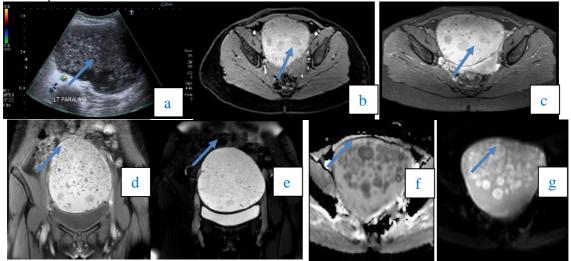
Grey scale Ultrasound image (a) showing a large complex (cystic and solid), avascular left adnexal mass with multiple internal echogenic foci. MRI axial T1WI pre (b) and post contrast (c) showing a non-enhancing predominantly high T1 signal lesion with innumerable variably-sized and shaped floating debris contents which are hypointense on both T1 and T2-WI. Coronal T2WI (d) and T2 fat suppression (e) shows predominantly high T2 signal with no suppression on fat suppressed sequence. There is no diffusion restriction in DWI (f) and ADC map (g).
